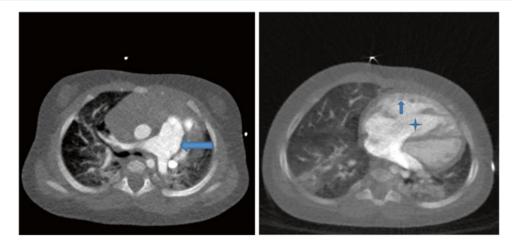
Evaluation of cardiovascular system in patients with BPD using CTA. Signs of pulmonary hypertension in a patient with mild to moderate BPD: *Left*—enlarged pulmonary artery (*arrow*); *right*—enlarged right ventricle (*star*) with hypertrophy (*arrow*). Courtesy of Andrew Mong, (CHOP)
